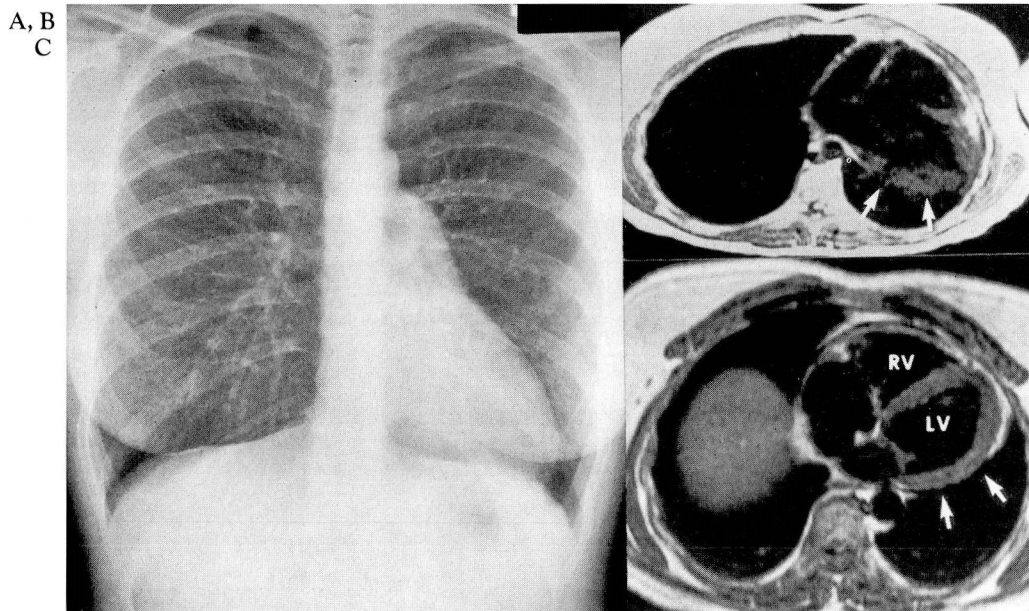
Posteroanterior chest radiograph shows enlargement of the pulmonary artery segment and the heart shifted into the left hemithorax. FIGURE 1B. Transverse gated magnetic resonance image shows rotation of the heart into the left hemithorax and blurring of the posterior left ventricular border (arrows). FIGURE 1C. Transverse gated magnetic resonance image shows normal biventricular size and axis. The left posterior cardiac border is distinct (arrows). RV=right ventricle; LV=left ventricle. (Reproduced from Schiavone and O'Donnell¹ with permission.
